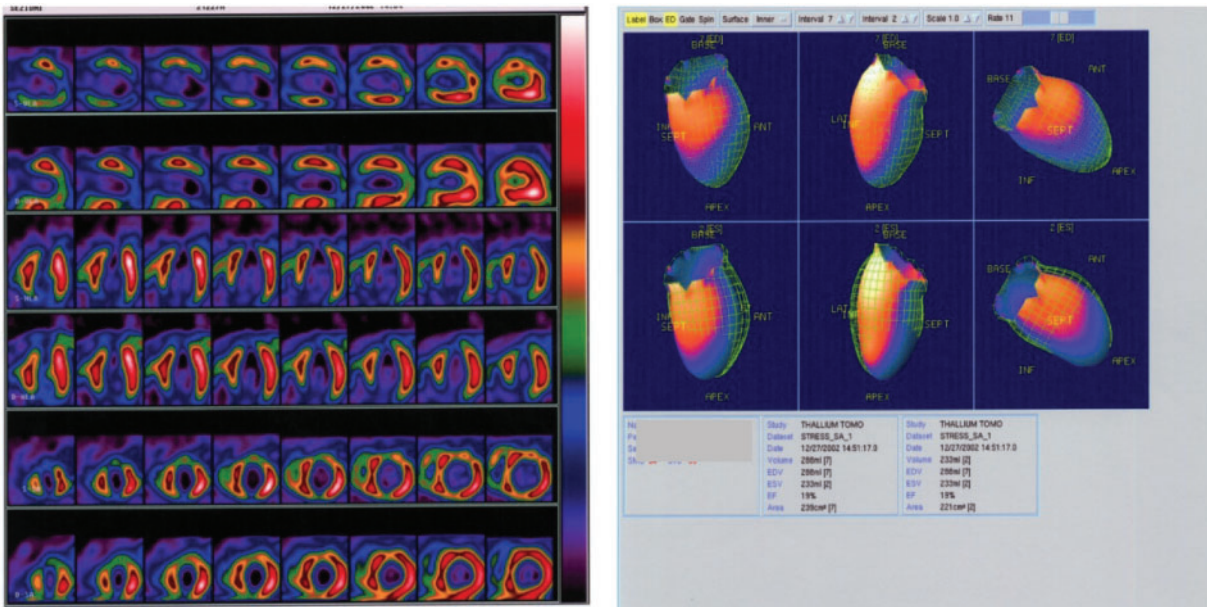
Myocardial perfusion scintigraphy and left ventriculography showing dilated left ventricle with left ventricular ejection fraction 19%. Reversible perfusion defects on the antero-septal wall and fixed apical perfusion defect.
